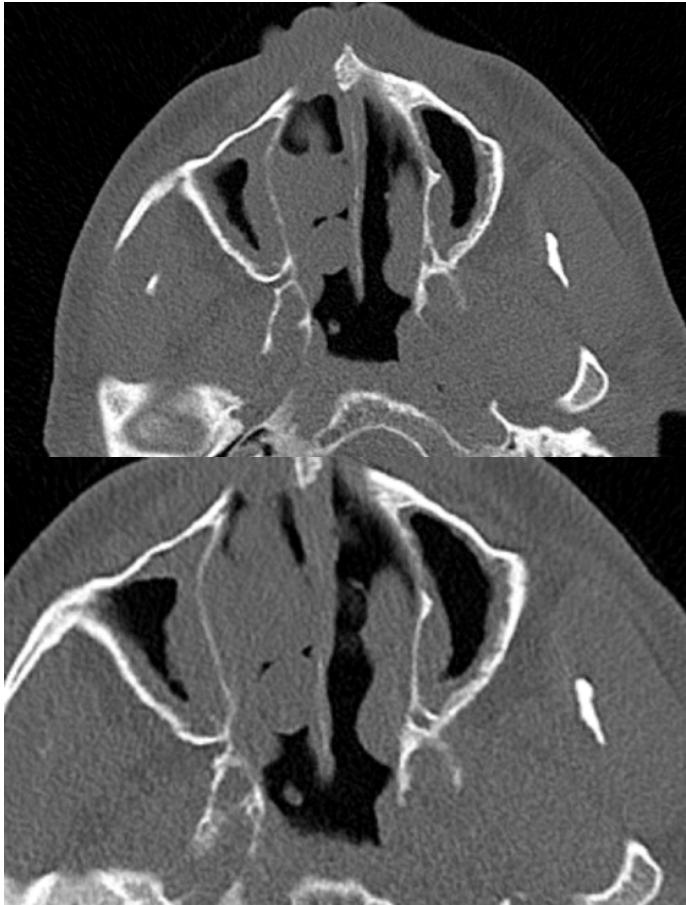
Paranasal sinus CT
